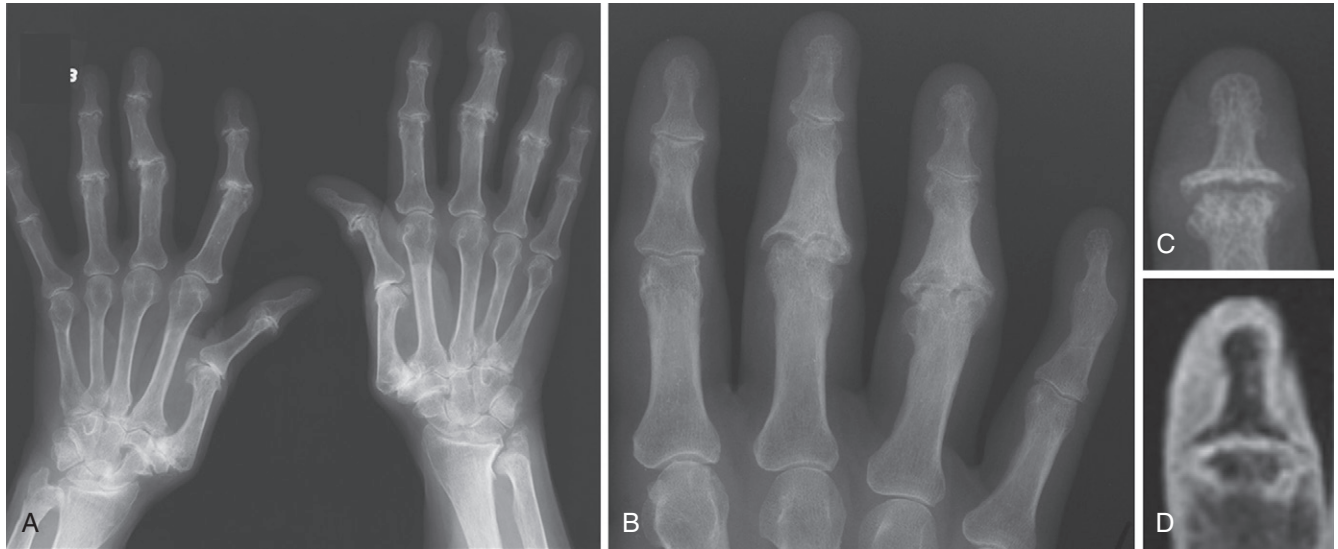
Osteoarthritis of the hand (x-ray and magnetic resonance imaging [MRI]). A, X-ray shows asymmetric cartilage space narrowing at the proximal and distal interphalangeal joints, the first carpometacarpal joints, and the scaphoid-trapezium-trapezoid articulations. Subluxation at the first carpometacarpal joint and secondary hyperextension at the metacarpophalangeal joints are characteristic deformities of osteoarthritis. B, “Gull wing” deformities in erosive osteoarthritis: Cartilage loss and bone remodeling at the third and fourth proximal interphalangeal joints produce a gull wing appearance. X-ray (C) and coronal MRI (D) of distal interphalangeal joint show osteophyte and central erosions/collapse of the bone plate, representing severe osteoarthritis. (C and D Courtesy Dr. Ida Haugen, Oslo, Norway.)
